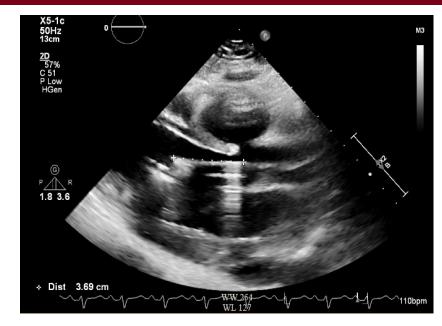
Impella placement seen on echocardiogram
